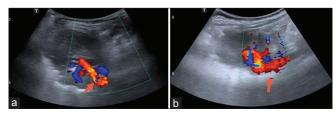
(a) Axial and (b) longitudinal color Doppler ultrasonography images showing blood supply of the lesion originating from the thoracic aorta
